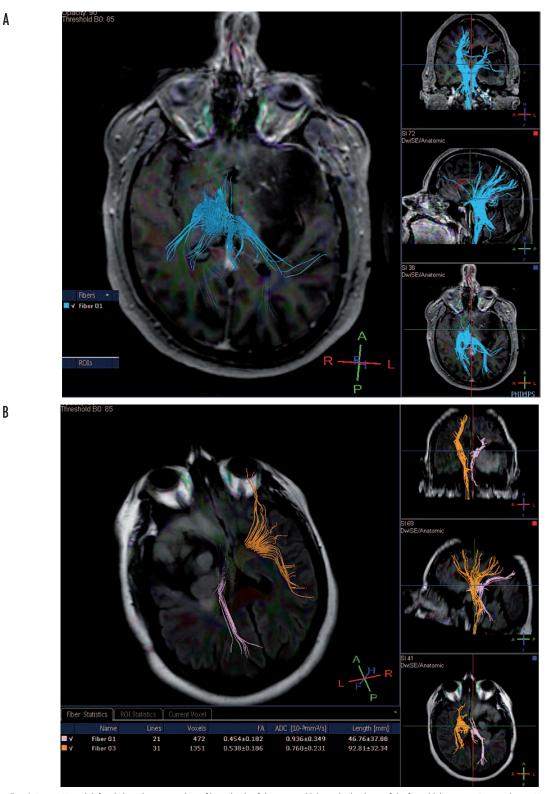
Patient KK with left-sided insular tumour that infiltrated pole of the temporal lobe and orbital gyri of the frontal lobe – type 5A according to Yasargil classification. MR tractography superimposed on morphological images (T1-weighted 3D) fused with colour-coded fractionated anisotropy map. Loss of fibres in corticospinal and corticopontine tracts on the left. Dislocation of corticospinal and corticopontine tracts on the left incurred by tumour of temporal lobe and insula is present. Patient with mild right-sided hemiparesis (grade IV according to Lovett scale)
